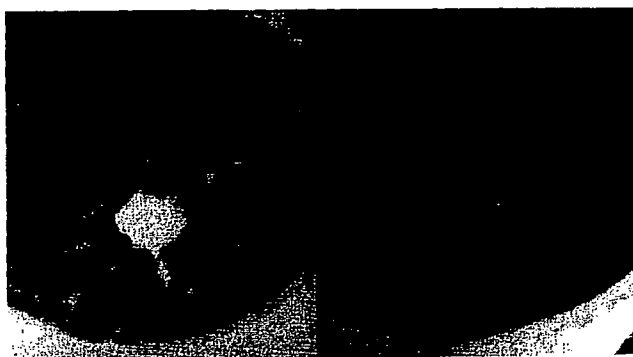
High-resolution computed tomographic image of solid-density type adenocarcinoma (tumor shadow disappearance rate $< 50\%$).
